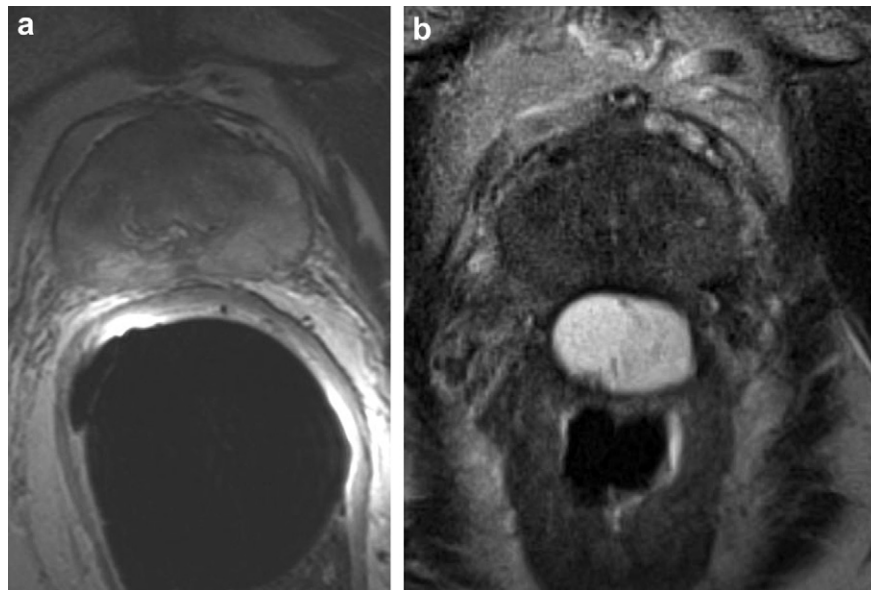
(a) T2-weighted axial endorectal coil MRI before spacer injection showing almost no separation between prostate and rectum. (b) T2-weighted axial MRI after spacer injection showing new separation between prostate and rectum.
